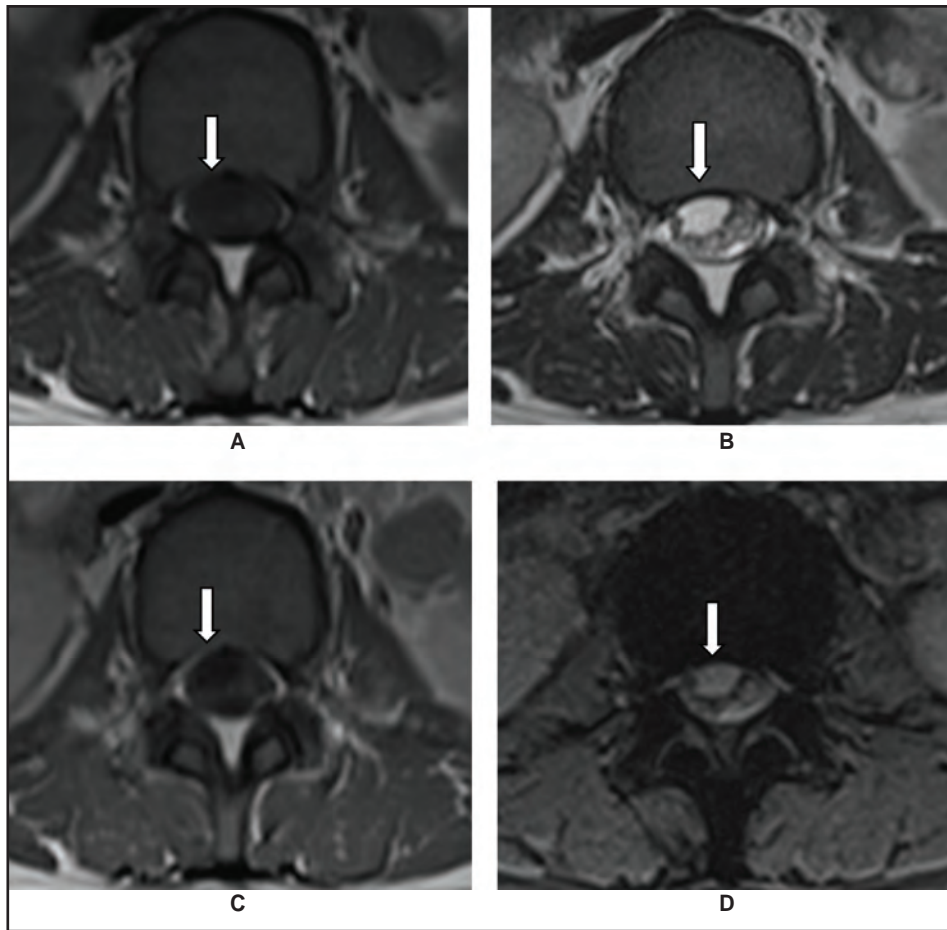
Lumbar MRI – axial section. Axial lumbar MRI at L3 level revealed intradural cystic lesion at anterior aspect of the thecal sac which, (A) demonstrates low signal on T1-weighted image, (B) bright on T2-weighted image, and (C) not enhanced on post gadolinium administration. (D) Gradient echo sequence (GRE) revealed no evidence of hematoma.
